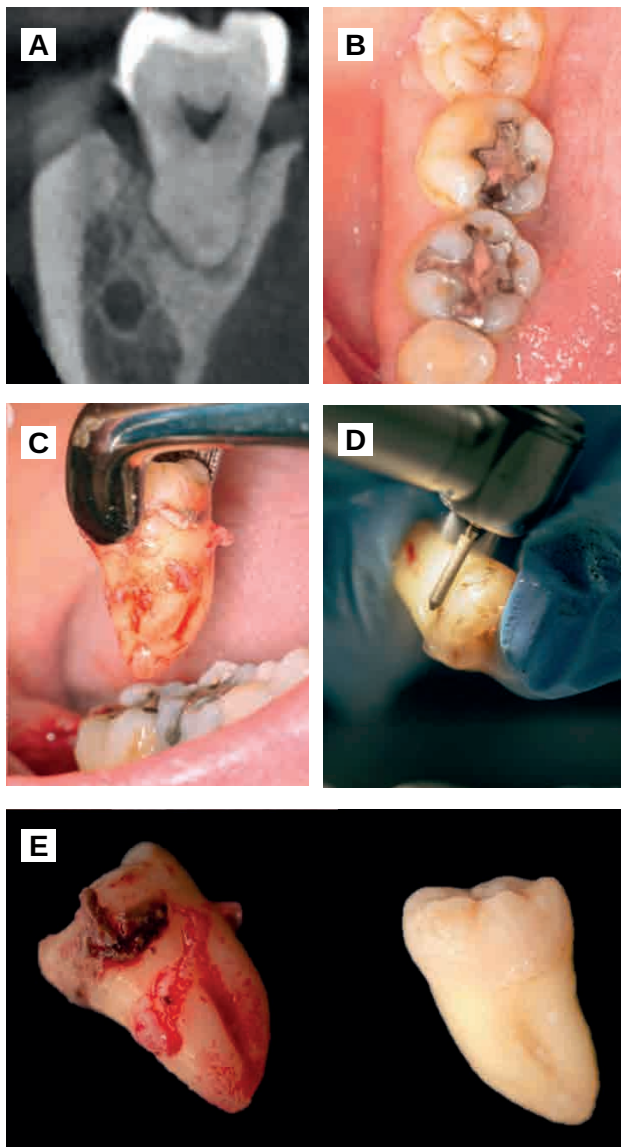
A. Orthoradial section of the CBCT at 4.8. B. Occlusal view of 4.8. C. Exodontia of 4.8. D. Cleaning of the root surface of 4.8 with a diamond turbine bur. E. Condition of 4.8 before and after preparation.
